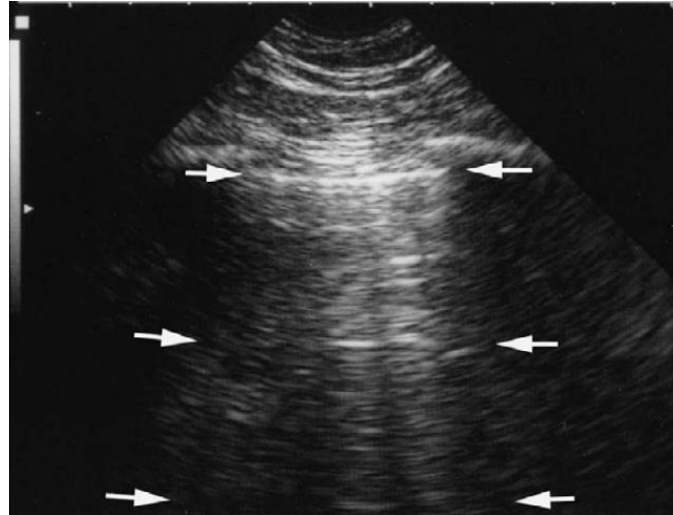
The Normal Lung Visualised by Lung Ultrasound. In a normal lung, most of the image comprises artefacts as the ultrasonic waves bounce off air. Only when there is pathology which reduces air can we begin to see true images with the ultrasonic waves. The shadows underneath the arrows are caused by the ribs blocking the ultrasonic waves. The hyperechoic white line between the top arrows is the pleural line. The subsequent hyperechoic lines indicated by the other arrows are reverberations of the ultrasonic waves off the pleural line and are artefacts called A-lines. (Source: Lichtenstein 2009)
